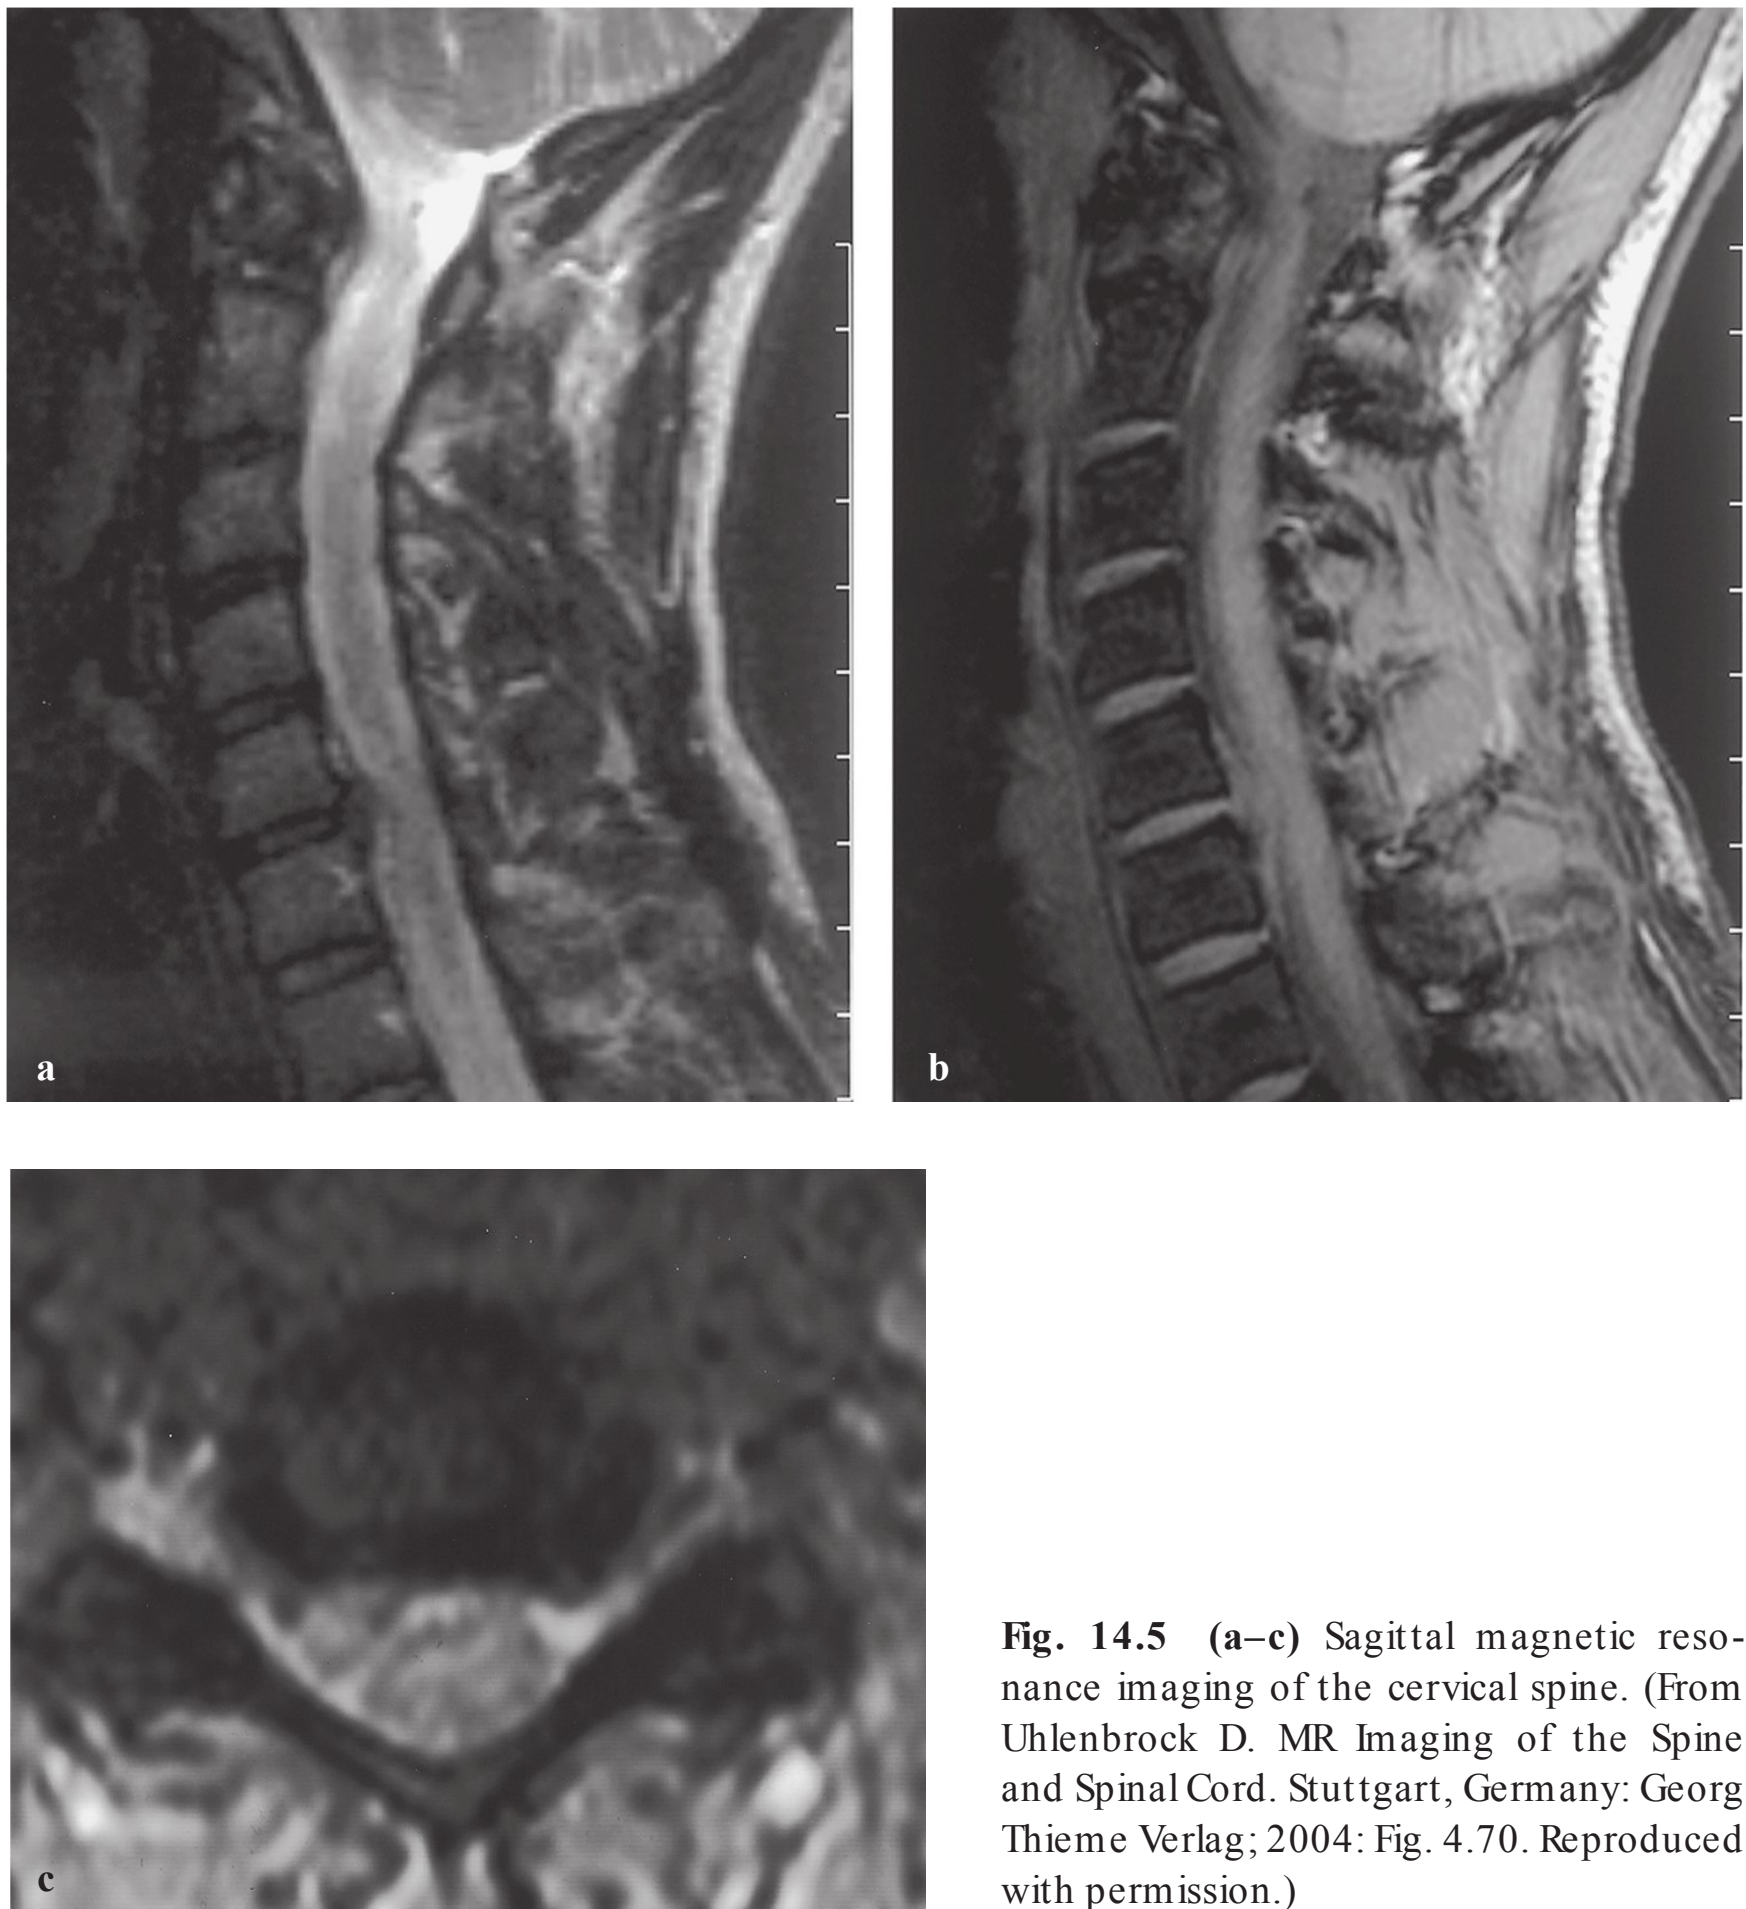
(a–c) Sagittal magnetic resonance imaging of the cervical spine. (From Uhlenbrock D. MR Imaging of the Spine and Spinal Cord. Stuttgart, Germany: Georg Thieme Verlag; 2004: Fig. 4.70. Reproduced with permission.)
